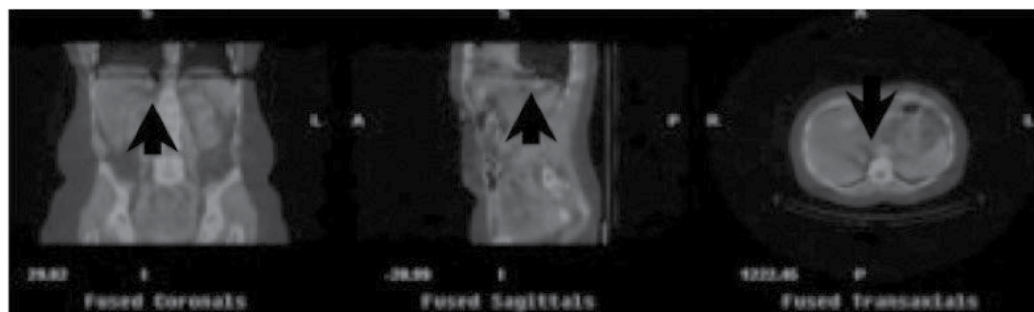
SPECT/CT imaging demonstrates focal tracer uptake in the right suprarenal region (*arrow*) suspicious for a right adrenal pheochromocytoma.
